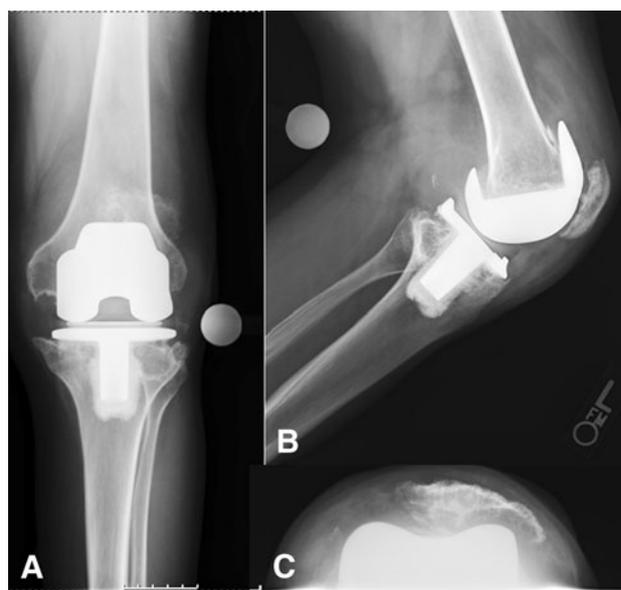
Radiographs in three planes (A–C) of a left knee 25 years after TKA in a male patient, 17 years old at the time of the index procedure, are shown. This patient with multiple joint involvement was revision-free at latest followup and walks daily > 1 mile without walking aids.
